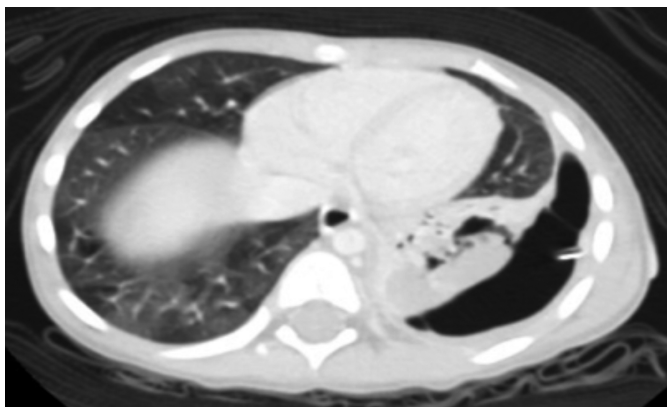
CT chest showing lobulated left pneumothorax.
